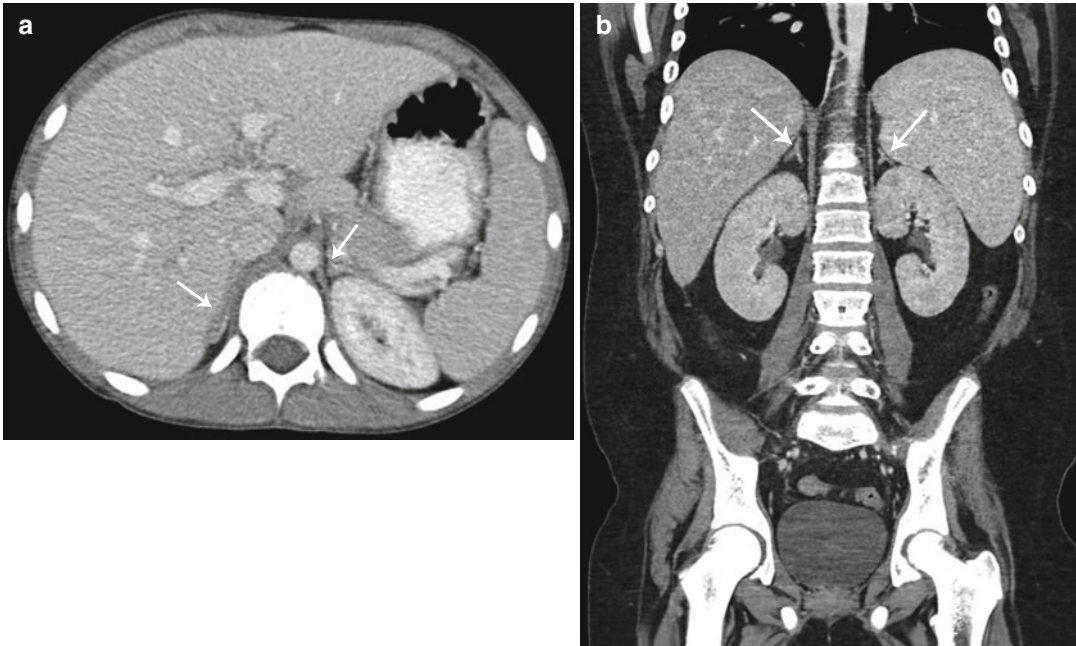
Normal adrenal gland – CT. Axial contrast-enhanced CT image in a 12-year-old girl (a) and coronal contrast-enhanced CT image in a 14-year-old boy (b)
